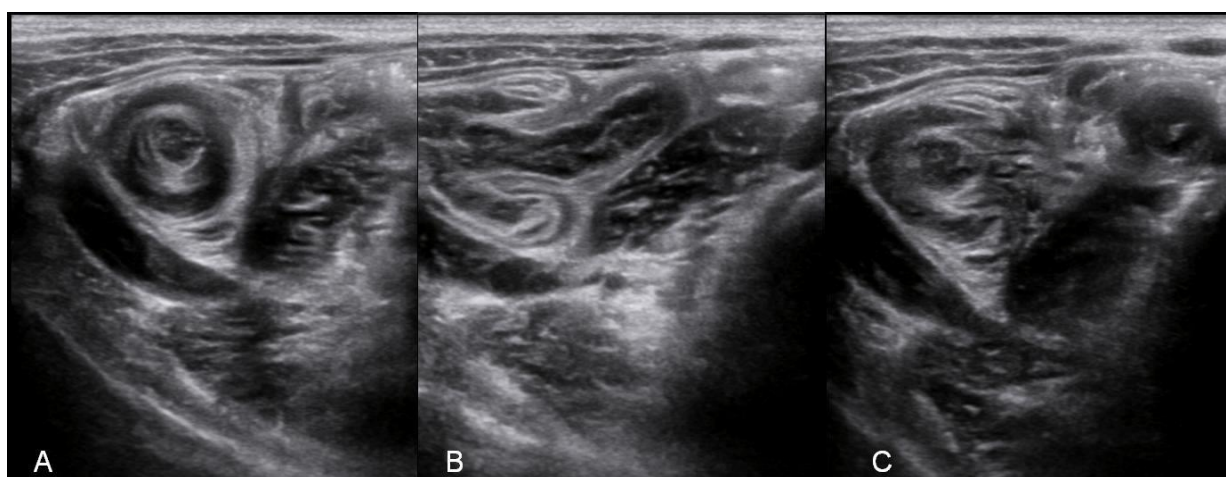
Ultrasound imaging of RLQ: Invagination target view in the vicinity of terminal ileum (A), adjacent terminal ileum with advancement of vermiform appendix into the cecum (B), Invagination target and target view of vermiform appendix tail with a thick layer of submucosa (C).
